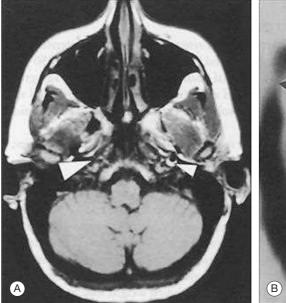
Magnetic Resonance Imaging (MRI) of Spontaneous Carotid Dissection. (A) T2-weighted MRI through the base of the skull demonstrates normal flow void in the right internal carotid (*large arrow*) and curvilinear high signal intensity in the left internal carotid (*small arrow*) caused by spontaneous dissection in a 52-year-old man with hypertension. (B) Magnetic resonance angiogram in the anterior oblique projection demonstrates an area of narrowing of the internal carotid artery caused by dissection (*arrow*) just distal to the bifurcation.
